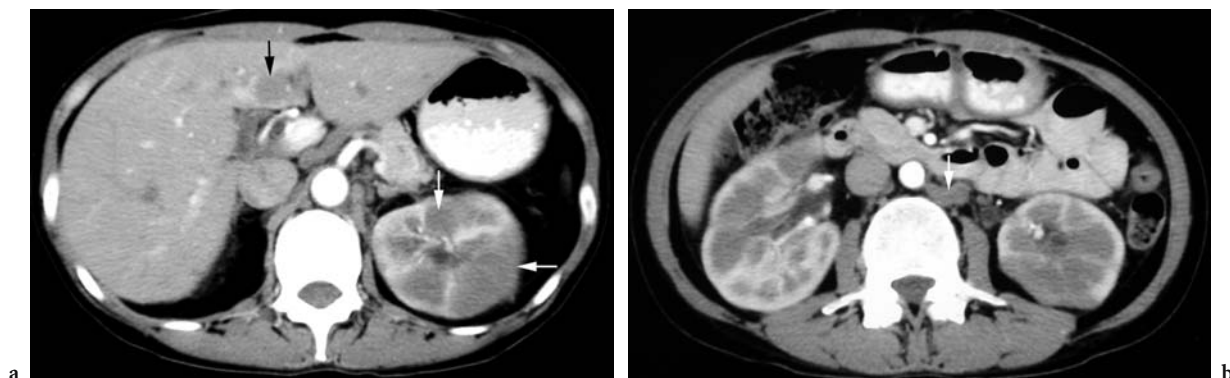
Acute lymphoblastic leukemia in a 52-year-old man. a Axial contrast-enhanced CT scan through the abdomen shows diffuse hypodense leukemic infiltration (*white arrows*) of the left kidney and a hypodense nodule (*black arrow*) in the segment IV of the liver. b Axial contrast-enhanced CT scan obtained caudad to a shows bilateral diffuse renal involvement and retroperitoneal lymphadenopathy (*arrow*).
